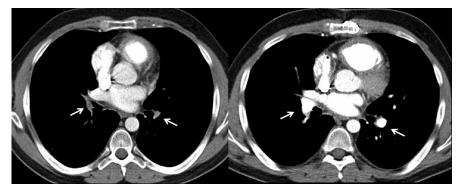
Axial multidetector computed tomography (MDCT) before (left image) and after (right image) pulmonary endarterectomy. Before surgery, there is occlusion and narrowing of right and left inferior lobar pulmonary arteries. After surgery, complete repermeabilisation (arrows) is shown. Pulmonary arteries returned to their normal diameter in the post-operative period.
